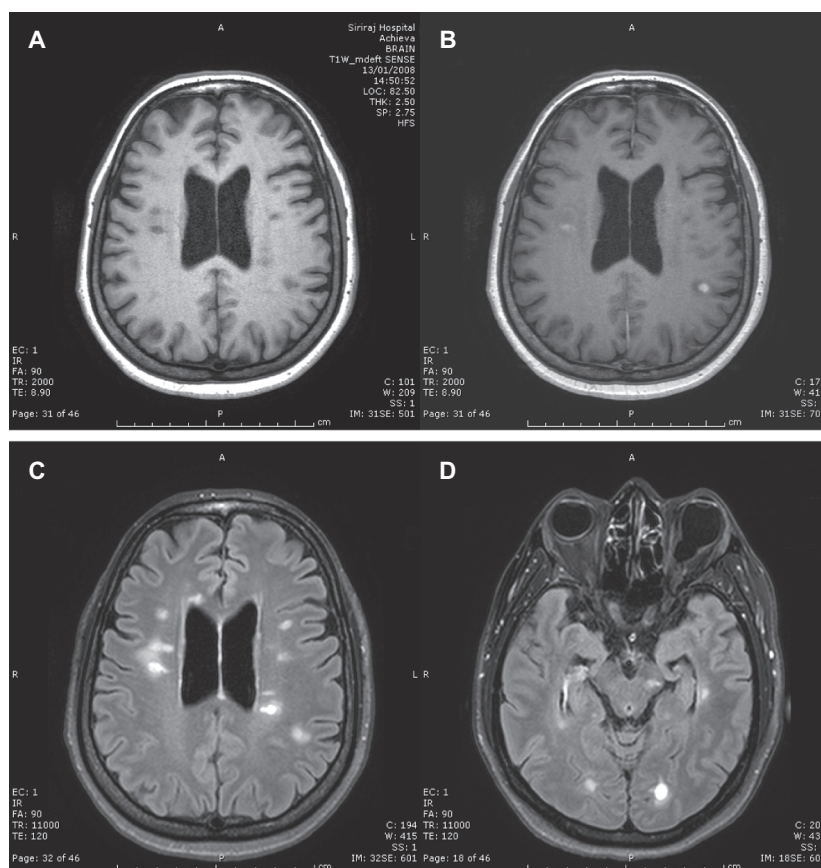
Axial brain MRI of a 44-year-old woman with relapsing–remitting multiple sclerosis. There were multiple hypointense lesions on T1-weighted image (A) and two enhanced lesions on the postgadolinium image (B). Axial FLAIR image showed nine lesions perpendicular to lateral ventricles with juxtacortical involvement (C) and one midbrain lesion (D).
